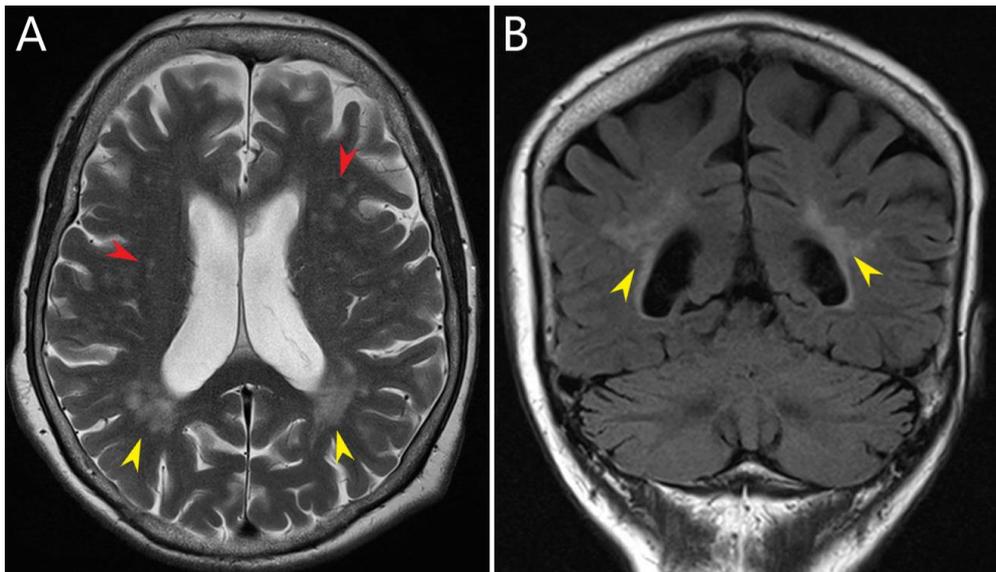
A) Periventricular white matter hyperintensities (yellow arrows) and deep white matter hyperintensities in T2-sequences. B) Periventricular white matter hyperintensities (yellow arrows) in Fluid-attenuated inversion recovery (FLAIR) sequences. (Copyright Dan Laukka)
